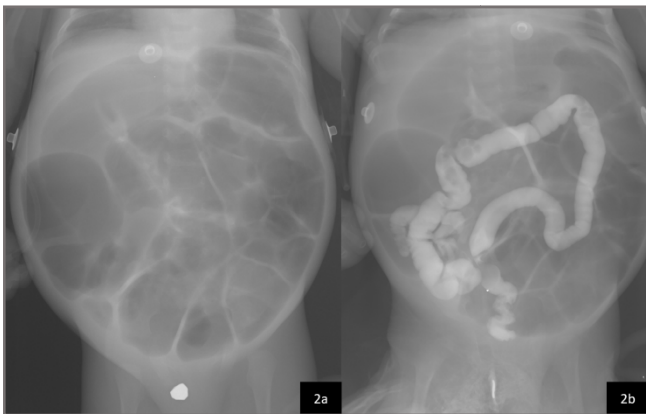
Abdominal radiograph showed multiple dilated bowel loops with absence of gas on rectum. (2b). Contrast enema demonstrated a microcolon with contrast filled on rectum, sigmoid colon, descending colon, transverse colon, ascending colon, redundant caecum and partially distal ileum
